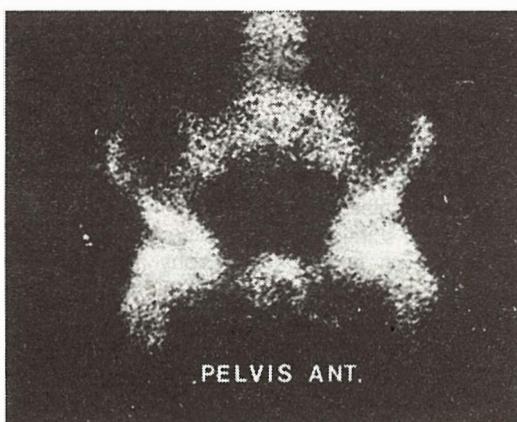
Planar scintigram of the pelvis – normal
